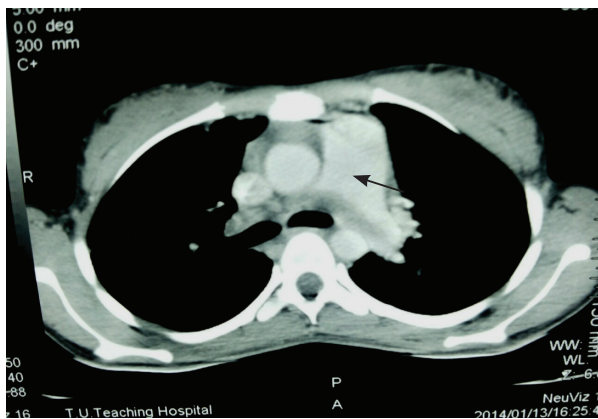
Computed tomography scan showing saddle thrombus in pulmonary artery (arrow)
